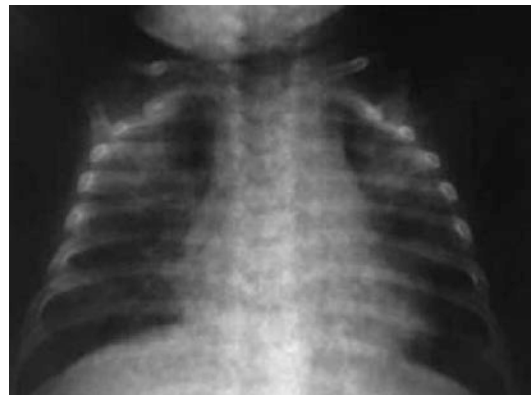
Pneumonia caused by *Pneumocystis jirovecii*. Chest X-rays of 6-month-old infant with a nodular reticle pattern and “ground glass” image associated with hypoxemia. *P. jirovecii* was confirmed in a sample of bronchoalveolar lavage
